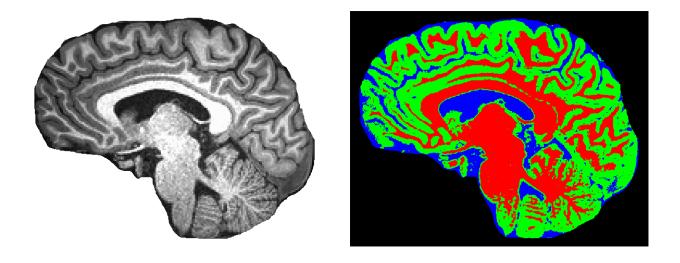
CRBM segmentation of a novel sagittal MRI slice.
